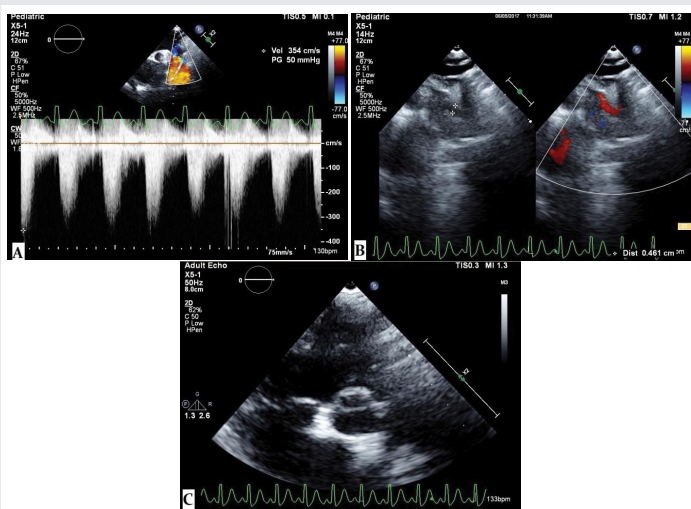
Transthoracic echocardiography showing severe post ductal coarctation of aorta with a peak pressure gradient of 50 mmHg (2A), a small patent ductus arteriosus (2B) and a bicuspid aortic valve (2C).
